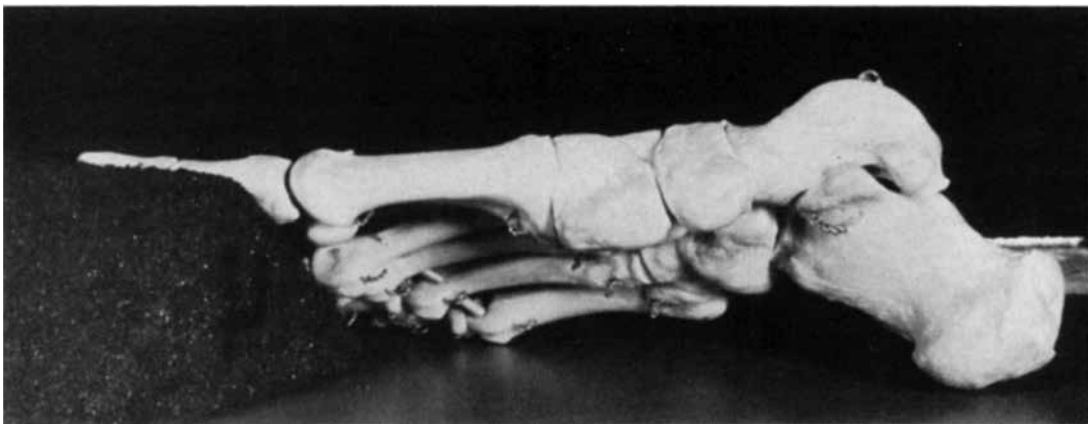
Model of the foot positioned with the medial side elevated to make the long axis and the dorsal surface of the navicular perpendicular to the x-ray beam and parallel to the film.
